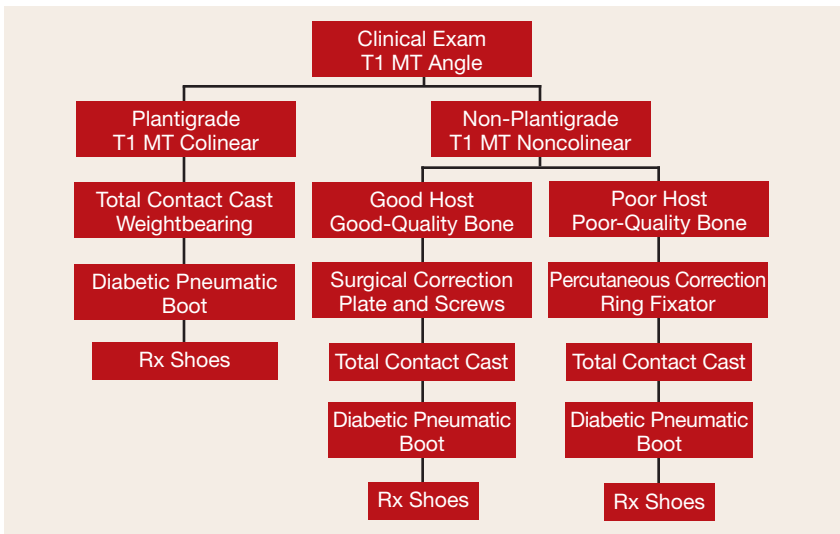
Treatment algorithm. (Abbreviations: T1 MT= lateral talar 1st metatarsal angle; Rx = prescription) The initial treatment decision is based on clinical determination as to whether the weight-bearing surface of the foot is plantigrade and capable of working with a commercially available depth-inlay shoe and custom foot orthosis. A foot deemed plantigrade generally poses a colinear talar–first metatarsal angle, as measured from weight-bearing plain films. Surgical decision-making is described in the text.
